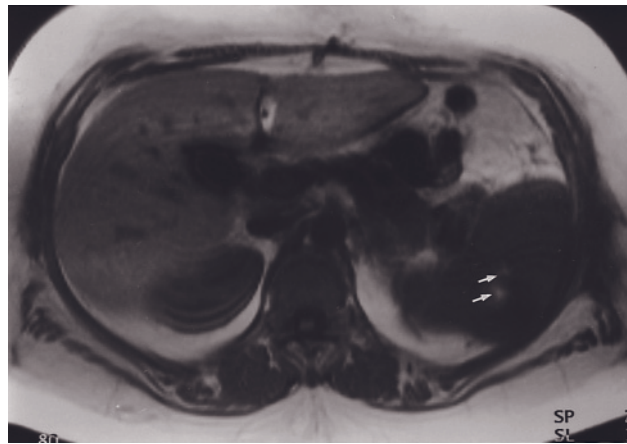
Epidermoid cyst. Immediate postgadolinium T1-weighted SGE image demonstrates a signal-void cystic lesion with peripheral septations.
